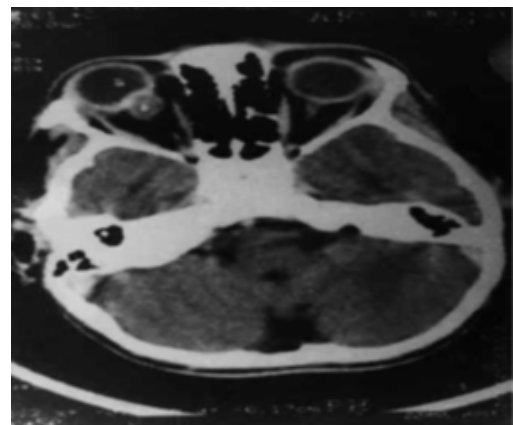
CT scan showing cyst in the muscle
